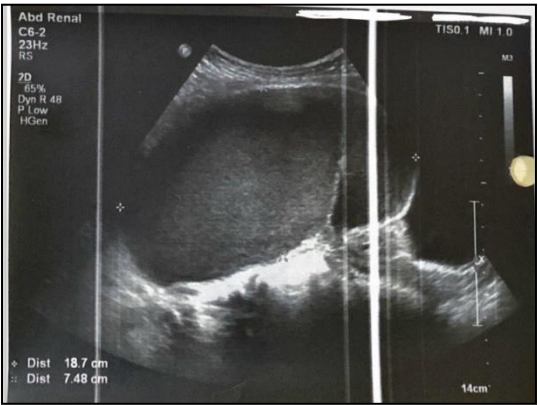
Ultrasound image of the mass.
